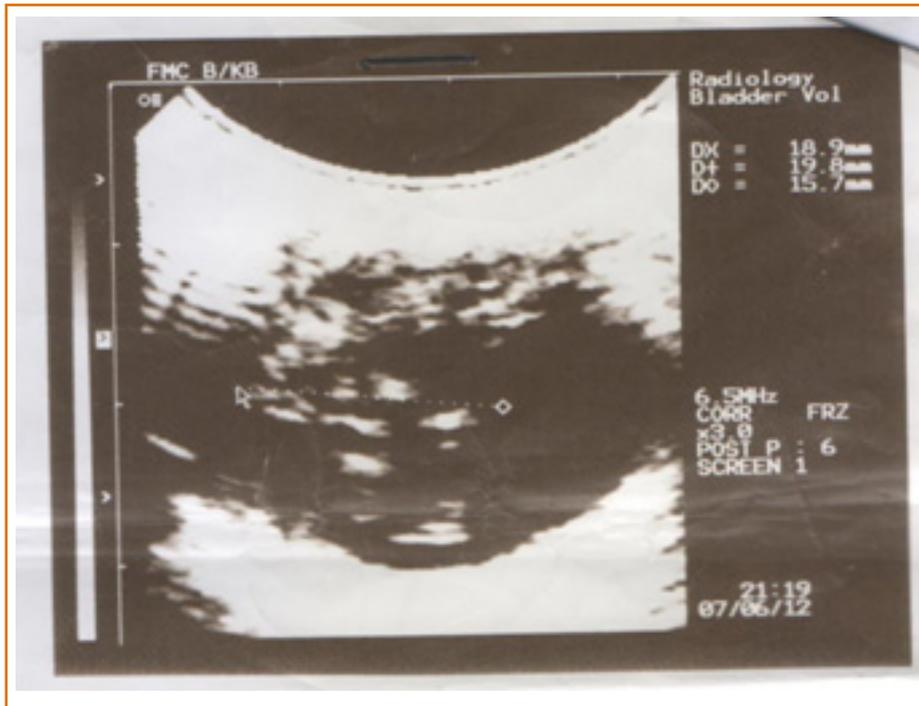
Ocular ultrasound, note vitreous haemorrhage right eye
